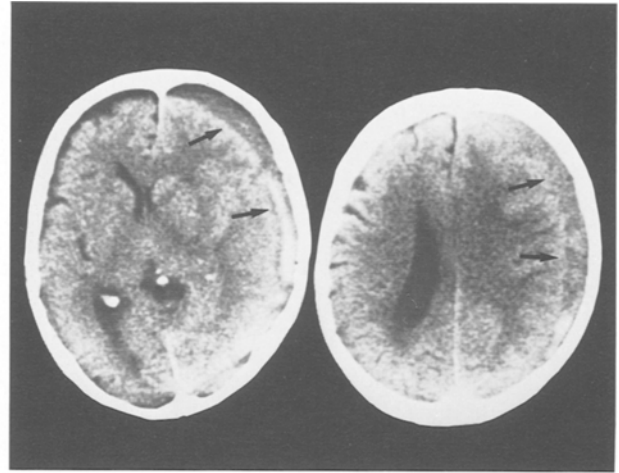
Computed tomography scans eleven days after the onset in case 1, disclosing enlargement of subdural haematoma with low density (arrows). Note the midline shift
